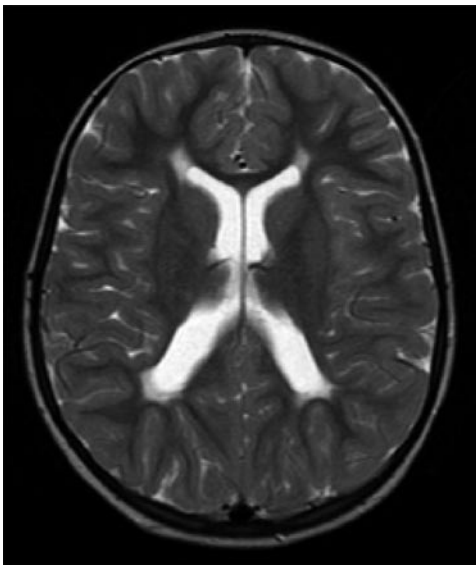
Chronic, severe periventricular white matter injury. T2-weighted axial magnetic resonance image of the brain at the level of the lateral ventricles. Note marked white matter loss in the posterior periventricular white matter with lack of space between ventricles and overlying cortex. Ventricles are dilated posteriorly with an irregular and scalloped border. (Adapted from [46])
